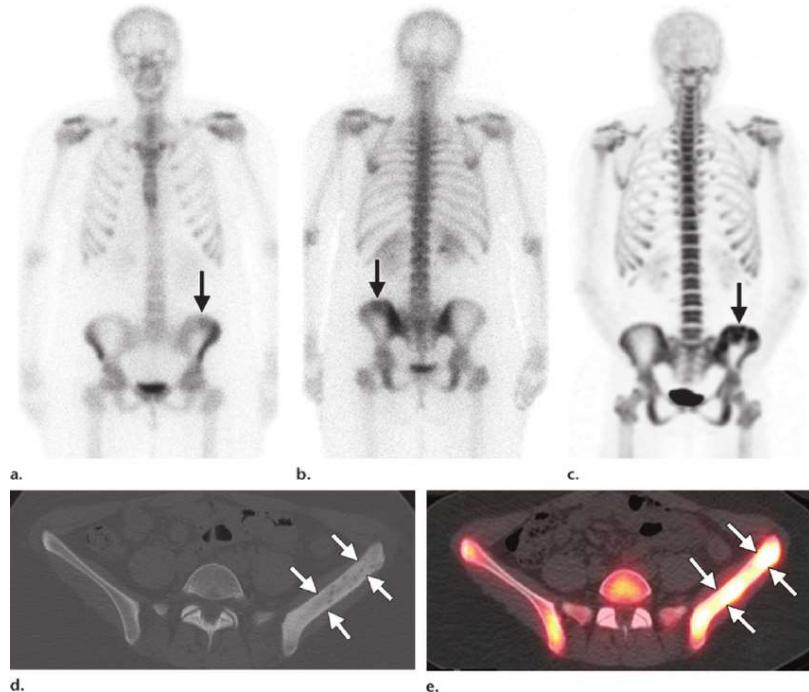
Bone imaging using SPECT: imaging identifies area of pathological bones formation, such a bone metastasis
